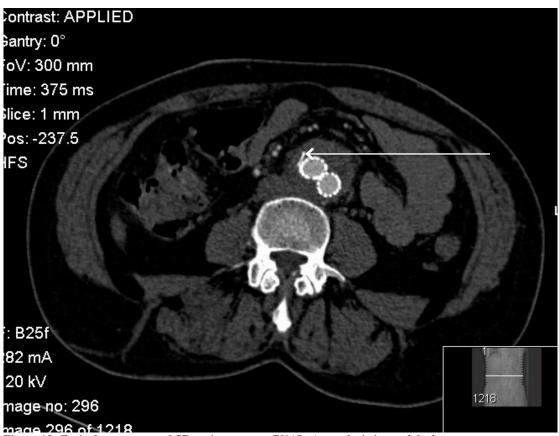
Typical appearance of CT angiogram post EVAR. Arrow depicting endoleak
